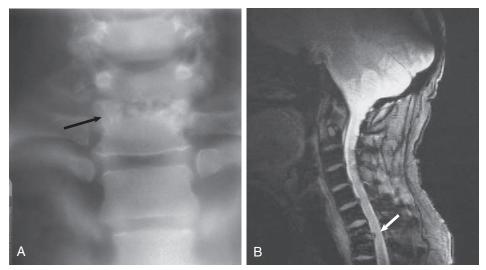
$Aβ_2M$ amyloidosis-associated spondyloarthropathy. (A) Destruction of an intervertebral disk (arrow) in the neck vertebrae of a long-term hemodialysis patient. (B) Magnetic resonance image of the same patient as in A. Note destruction of the intervertebral space and protrusion of material into the spinal canal (arrow).
